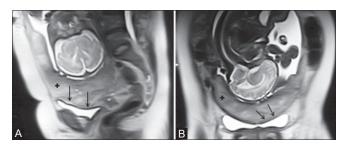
(A, B): (A, B) Complete placenta previa in a 30-year-old woman at 36 weeks of gestation. Sagittal and coronal T2 HASTE MR images show normal stratification of placenta (+) into lobules with a smooth continuous curved myometrial interface and layered appearance of myometrium (arrows)
